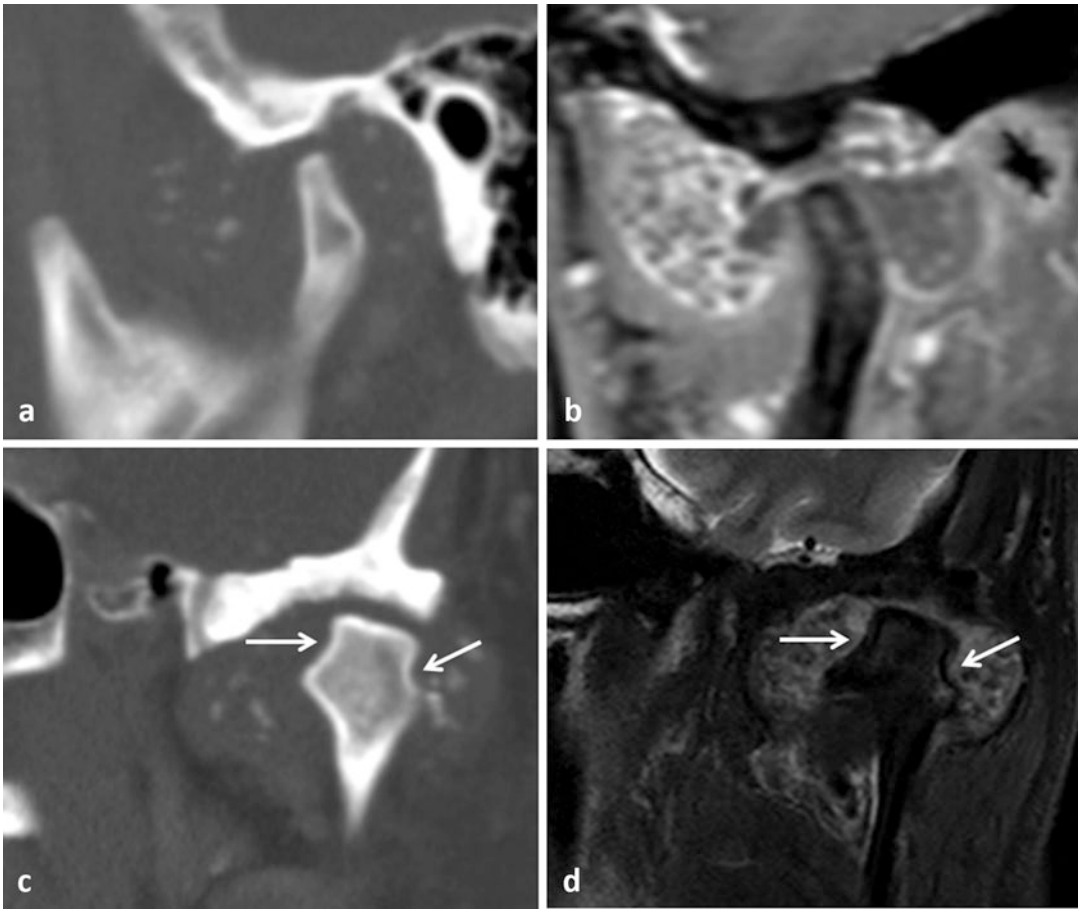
Synovial chondromatosis with calcified bodies in the superior joint space of the left temporomandibular joint. CT sagittal (a), post-gadolinium T1 fat saturation sagittal reconstruction (b), CT coronal (c), fat saturation T2 coronal (d). Synovial proliferation enhances with gadolinium and is hyperintense on T2. The “bodies” are low signal on all sequences whether they are calcified or not.
